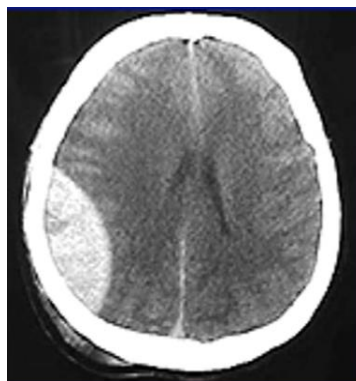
CT scan of epidural hematoma
